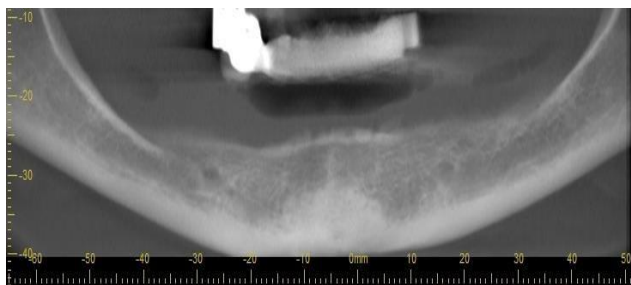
Preoperative CT upper jaw before implant placement
